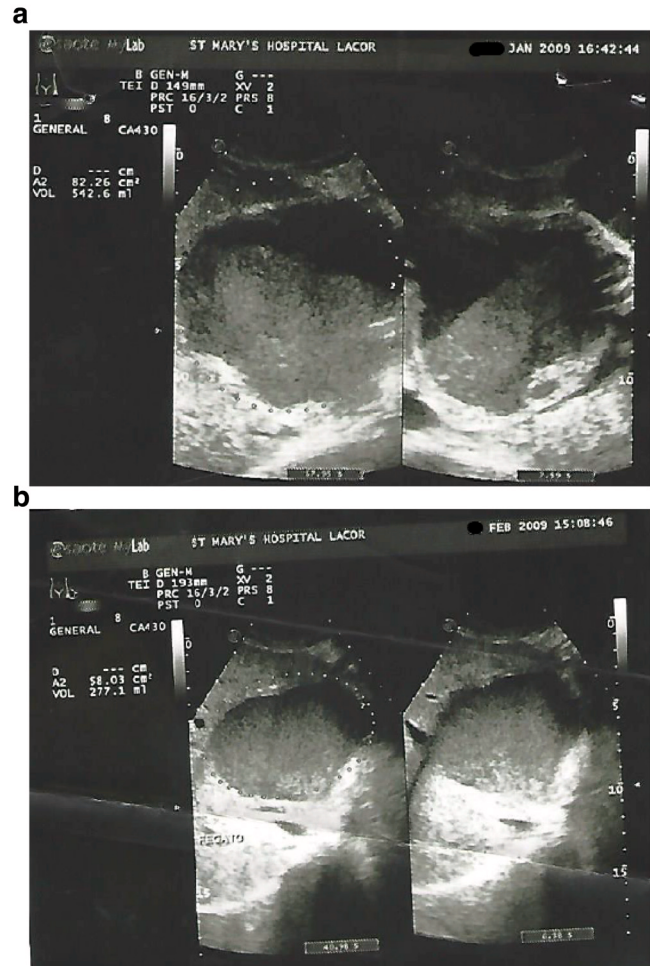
Abnormal ultrasound findings. (a) Abdominal Sonogram in transverse (left) and sagittal (right) sections showing an echo-complex fluid collection sub-hepatic left lobe liver, 10×8 cm in size. (b) Sonogram obtained 3 months following ultrasound-guided serial aspiration in transverse (left) and sagittal (right) sections show an echo complex indicating fluid collection in the sub-hepatic left lobe of the liver. The size of fluid collection had reduced to 277.1 cm³ in volume.
